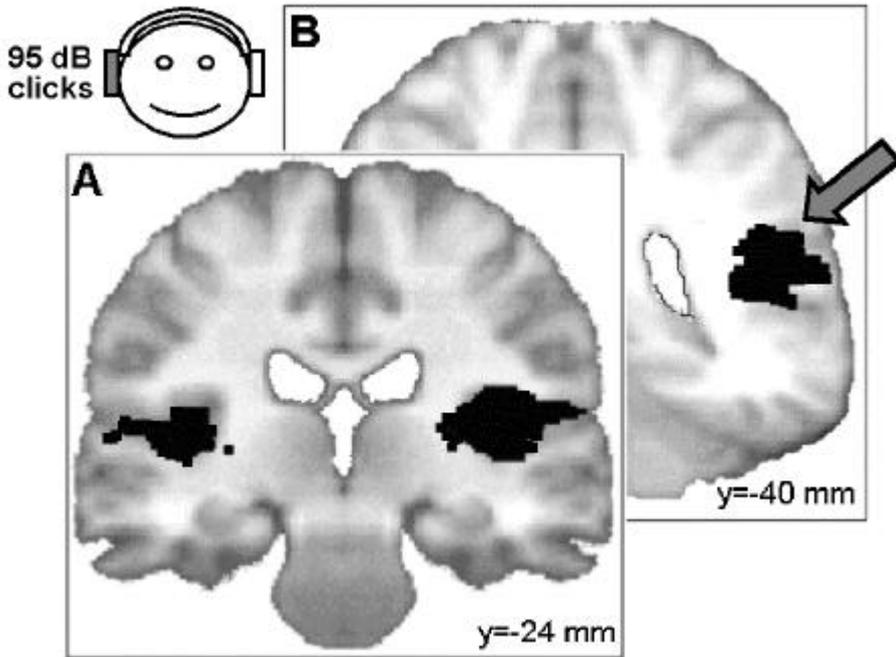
Areas of regional blood flow (rCBF) increase during auditory stimulation in VS patients projected on a coronal MRI section, 24 and 40 mm behind the anterior commissural line. The arrow points to the auditory association areas where rCBF showed significantly less activation in VS compared to controls. (Adapted from ref.⁵)
